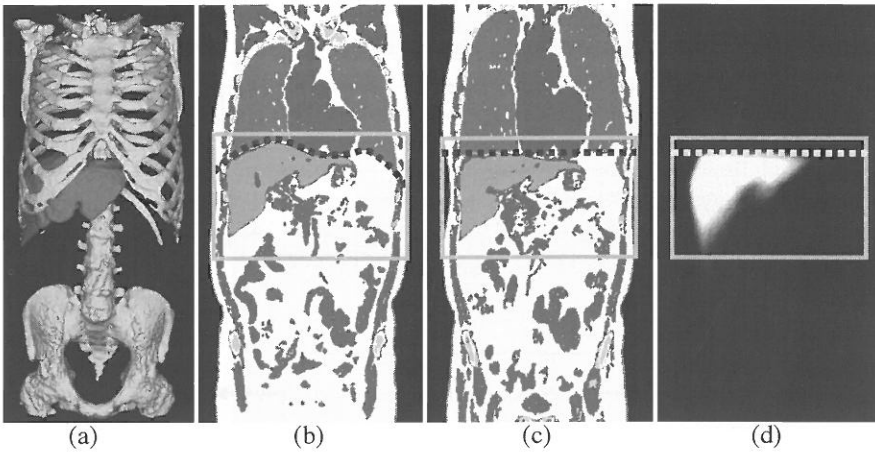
The probability estimation for liver location. (a) Pre-segmented liver and bone. (b) Spatial relations between liver, bone, and diaphragm (dotted line). (c) Normalizing liver position and shape by deforming the diaphragm and bone to a standard position (rectangle). (d) Spatial voting to generate a normalized likelihood image to show the probability of liver location using 80 patient cases of CT.
